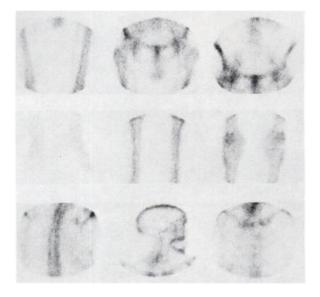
Example of bone scan graded as mild (upper limit). Note activity in femoral arteries, suggestive of arterial calcification. Radiographs also showed calcified arteries.
